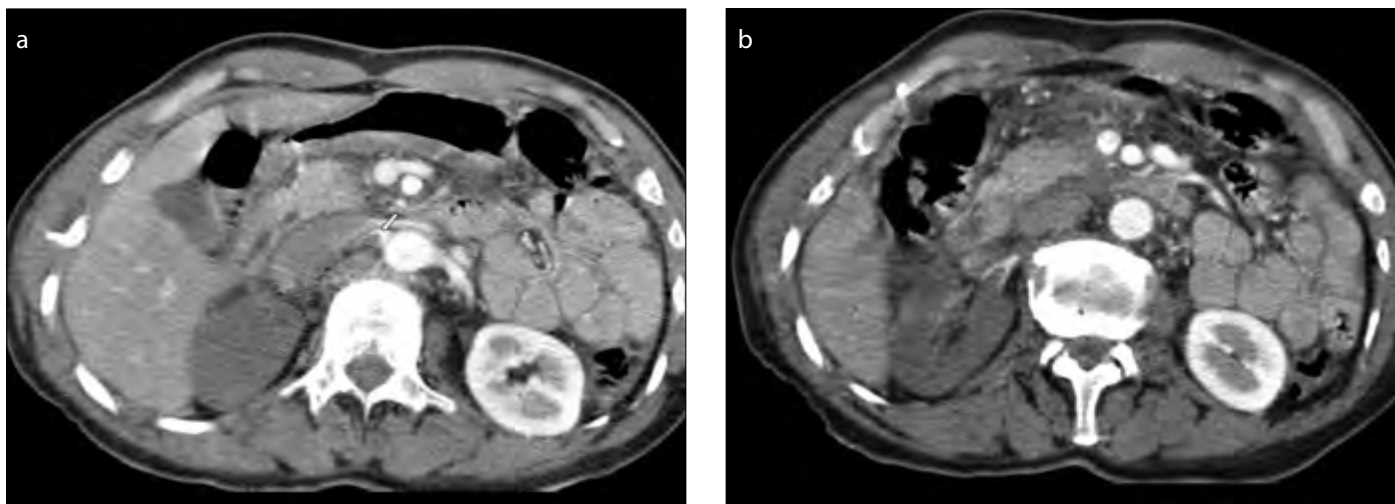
a, b. (a) Axial abdominal computed tomography (CT) of a patient after contrast administration. The patient is 45-years-old and he has right flank pain with hematuria and hypertension with no history of trauma. The sign of a false lumen without contrast filling at the level of the right renal artery orifice (arrow) and delay in the nephrogram phase in the right renal parenchyma, (b) There is no contrast enhancement in the right kidney even if the left kidney is in nephrogram phase
